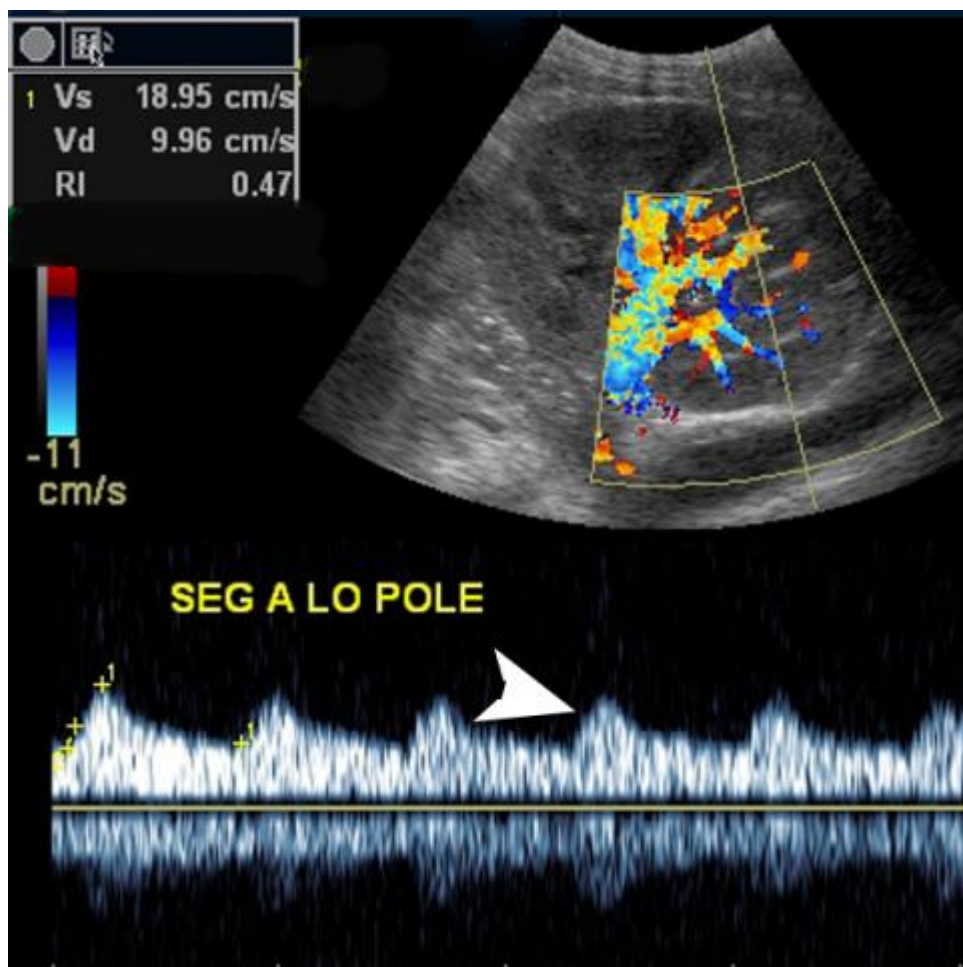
Renal transplant arterial stenosis. Spectral Doppler image demonstrates a delayed systolic upstroke and rounding of the systolic peak consistent with a tardus-parvus waveform (arrowhead).
